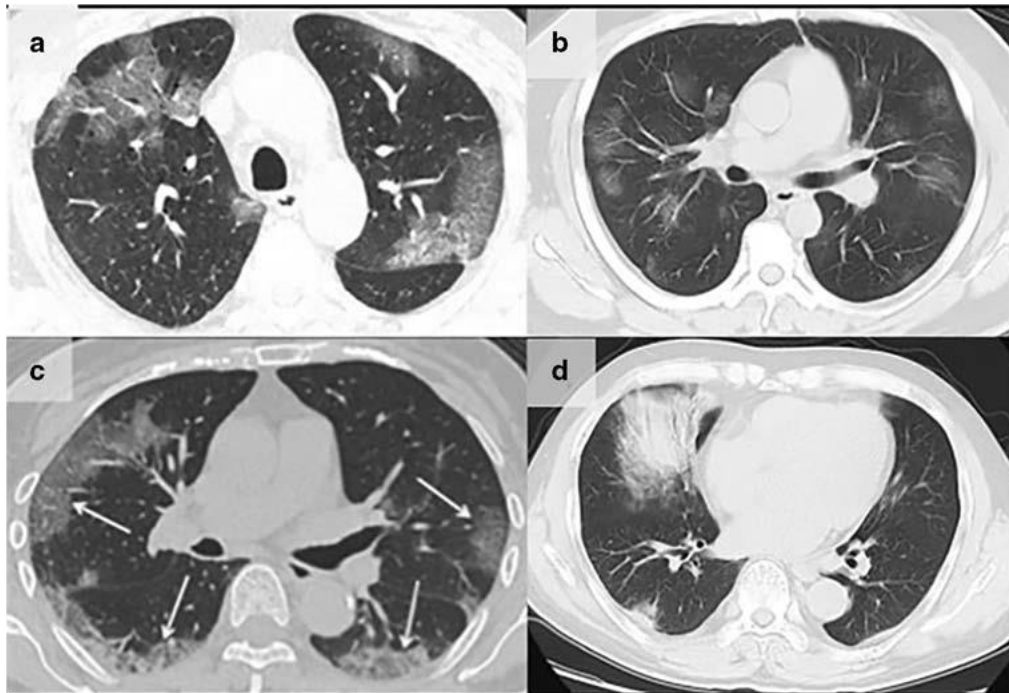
Typical CT findings of COVID-19 [1]. Chest CT shows:
